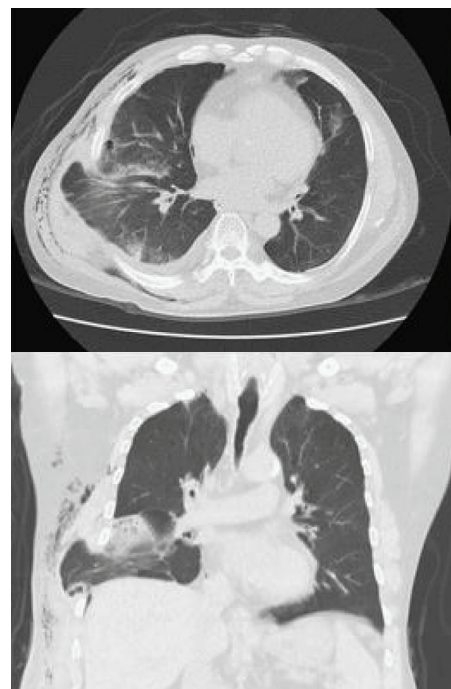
Chest computed tomography: Lung parenchyma protruding at the 7th intercostal space on the right posterolateral side without rib fracture.
